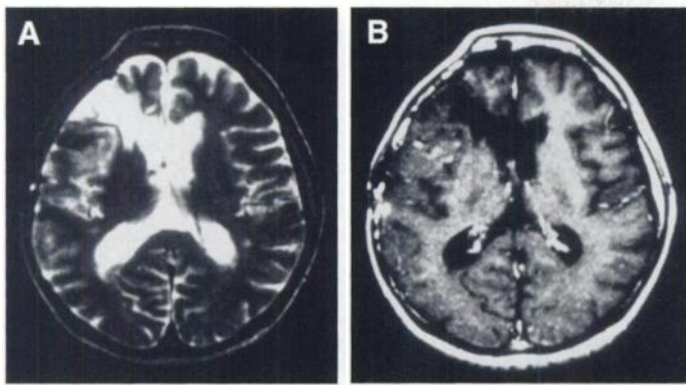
(A) T2-weighted MR image (TR2500/TE110) demonstrates a T2-prolonged lesion posterior to the surgical defect in the right frontal lobe. (B) After administration of Gd-DTPA, the T1-weighted MR image (TR500/TE18) demonstrates patchy enhancements on the lesion.
